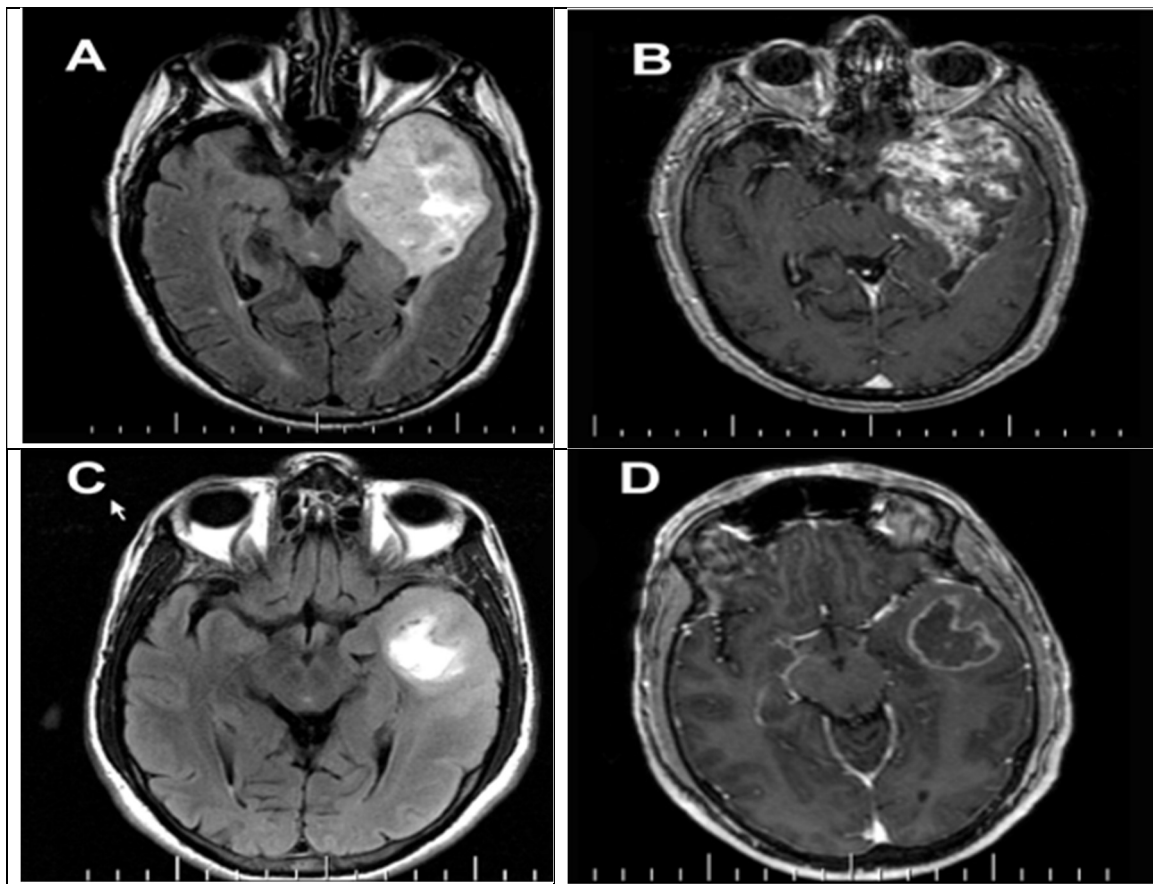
Sample MRI Slices From The TCGA-GBM Dataset Showing Glioblastoma Tumor Regions
